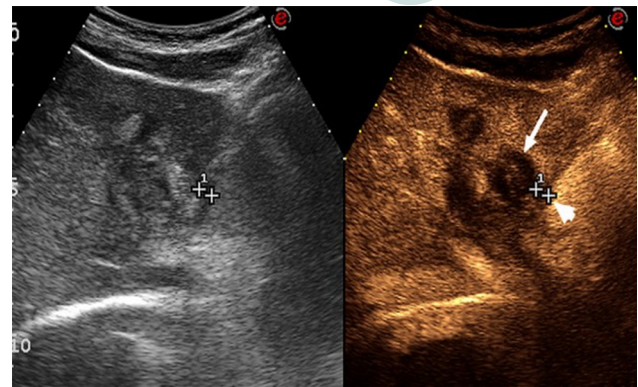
Oblique subcostal contrast-enhanced ultrasound scan of the left lobe of the liver performed a few days after laser thermal ablation, showing complete ablation of the metastasis with a 24 mm x 22 mm avascular area in segment II (arrows), at a distance of 4 mm from the diaphragm and pericardium (arrowheads)
